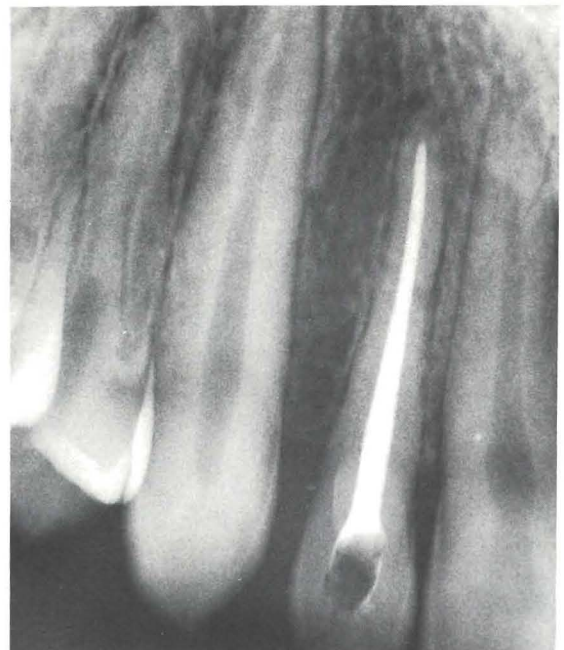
A radiograph taken one year after replantation. Narrowing of the root is evident, compared with Figures 2 and 5. There is no evidence, however, of replacement resorption. The root canal has been obturated with gutta-percha.
